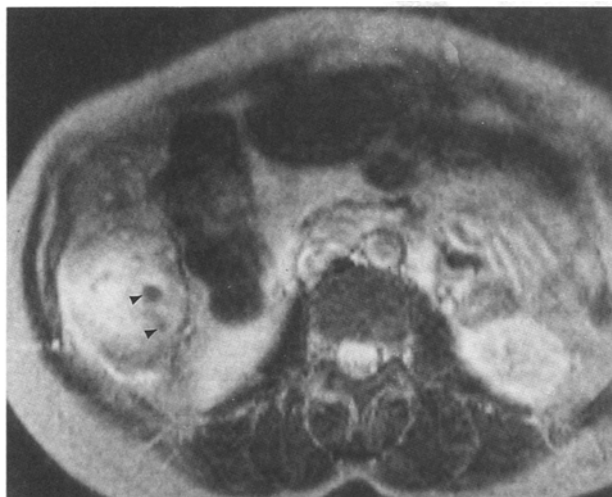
A 47-year-old woman with intrahepatic cholangiocarcinoma. T2-weighted (TR/TE = 2500/80 ms) SE MR image shows hyperintense well-defined tumor. Dilated biliary ducts are present in the tumor (arrowheads).
